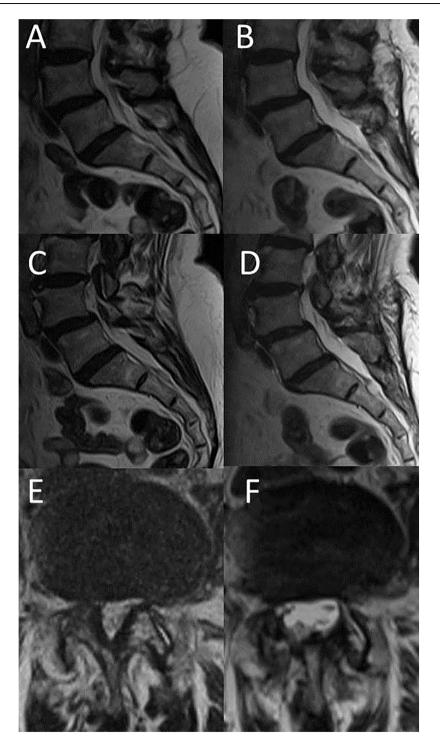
Pre-operative T2-weighted (A) sagittal medial cut, (C) sagittal lateral cut and (E) axial spinal lumbar MRI of a 69-year-old woman with a L4–L5 stenosis and spondylolisthesis. The patient was submitted to minimally invasive decompression at this level. One year FU T2-weighted (B) sagittal medial cut, (D) sagittal lateral cut and (F) axial spinal lumbar MRI showing the optimal decompression of dural sac and nerve roots with no change of the degree of spondylolisthesis.
